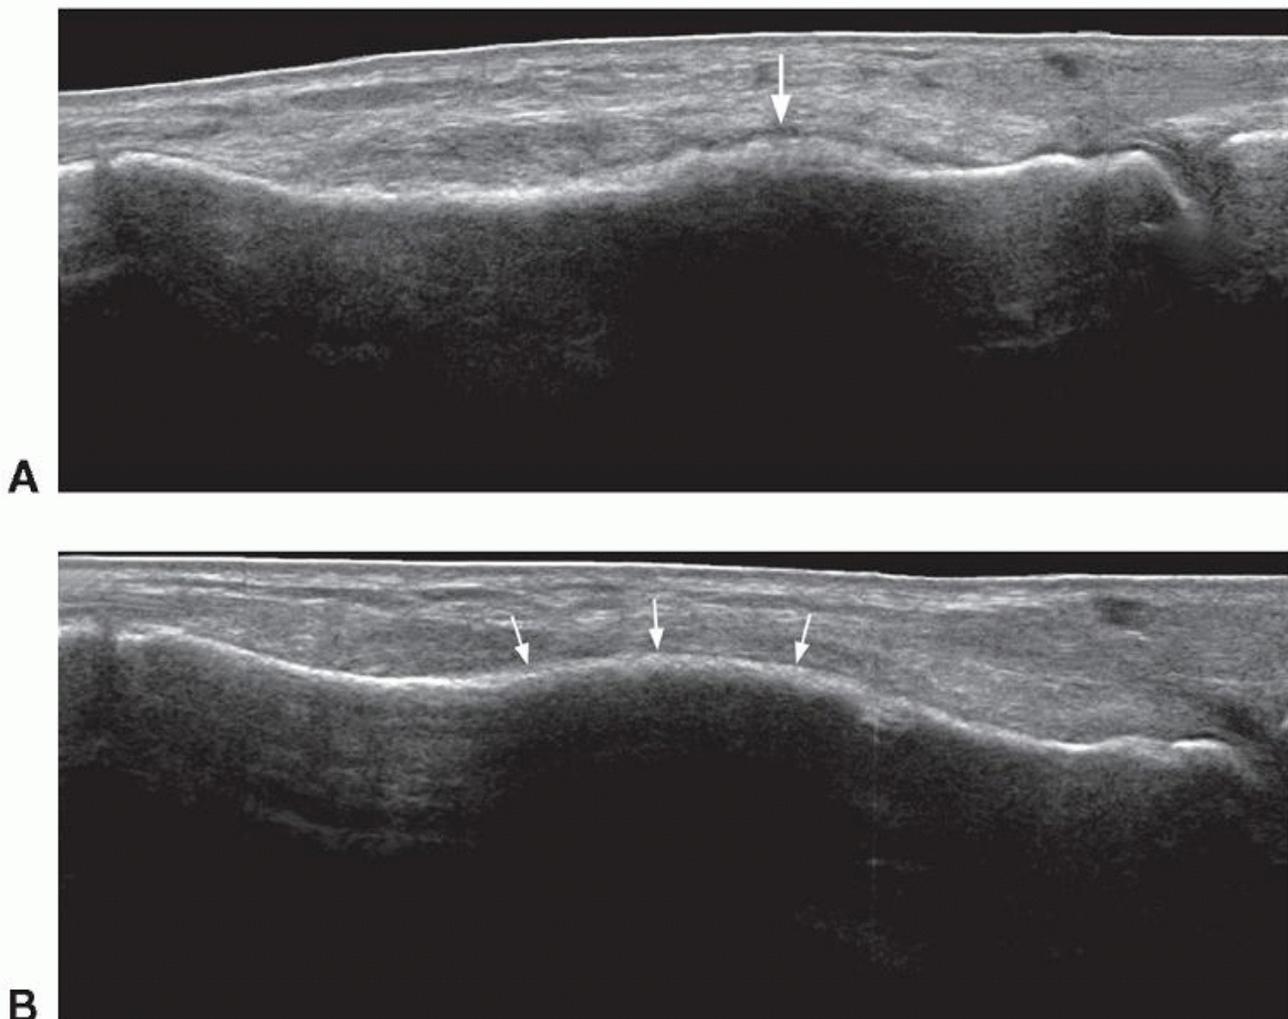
Longitudinal ultrasound of forefoot showing (A) an active fracture of the second metatarsal shaft with callus (arrow) and mild surrounding soft tissue swelling. B: On the contralateral foot, there is a healed fracture of the second metatarsal shaft with bone enlargement (arrows), no active callus, and no soft tissue swelling.
